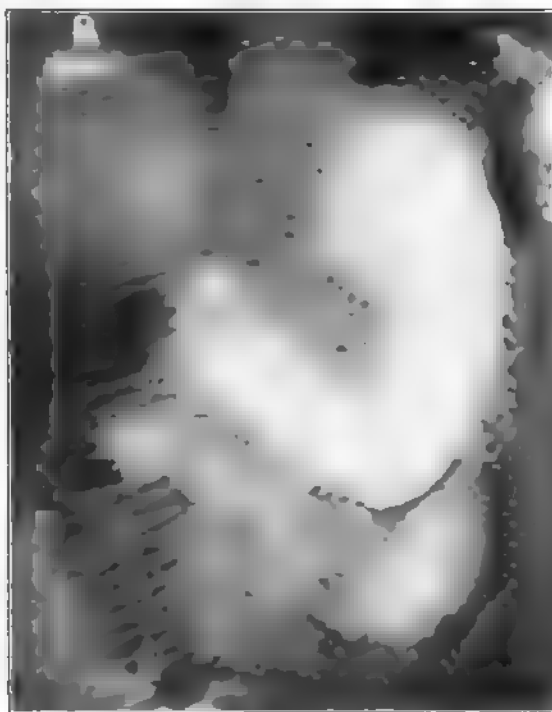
(Case No. A85,134; X-ray No. 30,801.) Male, aged forty-one. Filling defect on lesser curvature. No residue after six hours. Pylorus gaping. Operation: Carcinoma of stomach.
